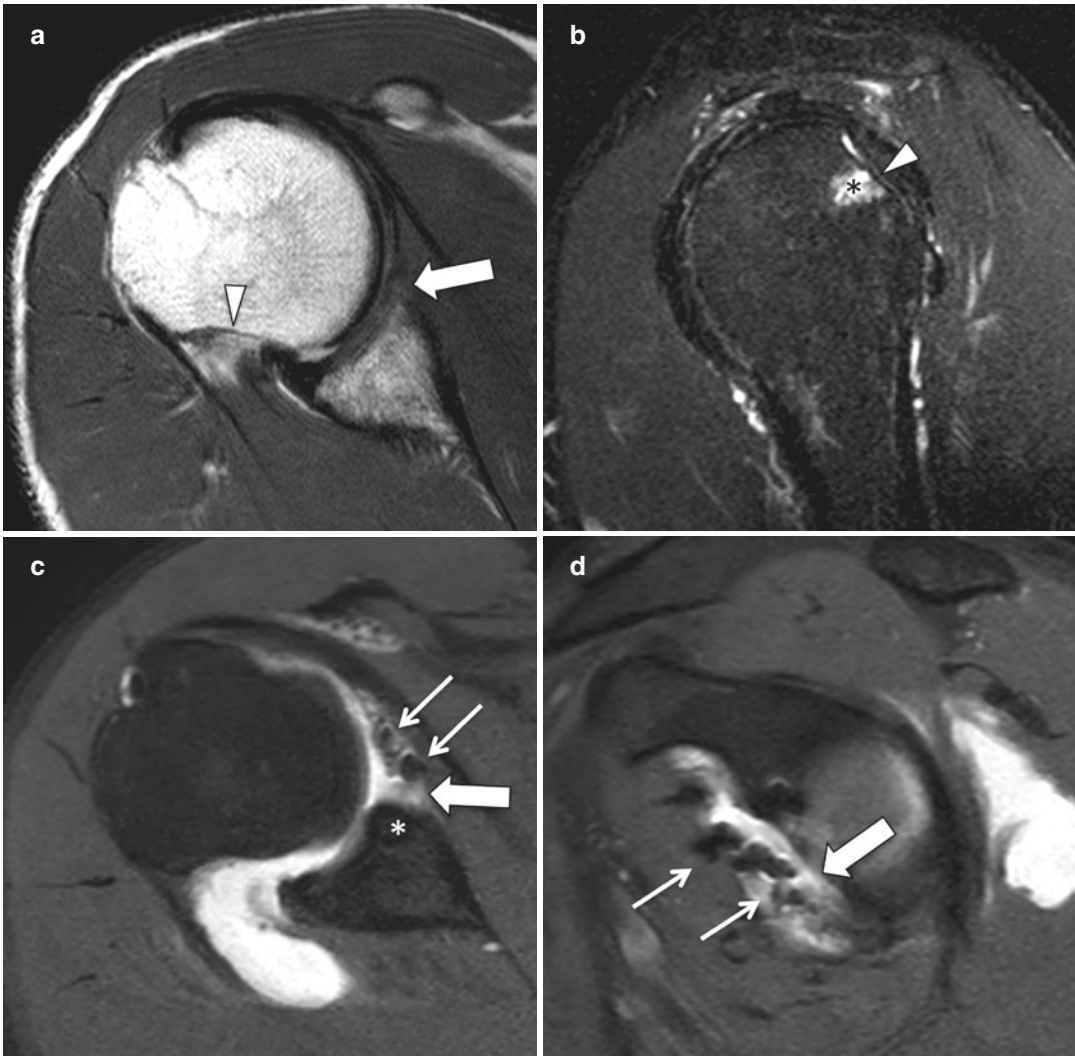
Recurrent postoperative anterior glenohumeral instability. Preoperative axial nonfat-saturated PD (a) and sagittal fat-saturated T2-weighted MR images (b) demonstrating a Hill-Sachs lesion (arrowheads) with bone marrow edema (black asterisk) and a small soft-tissue Bankart lesion (thick arrow) for which the patient underwent
